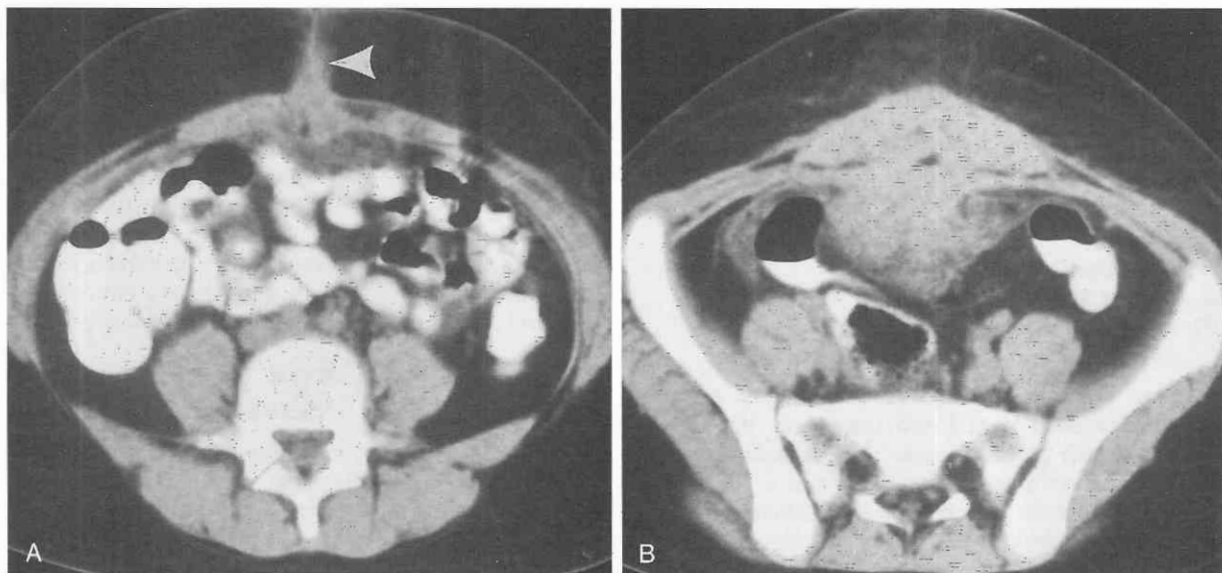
Pyourachus on serial CT scans. A, CT scan just below the level of the umbilicus shows a thickened fistulous tract (arrowhead) between the anterior abdominal wall and the rectus abdominis muscles. B, A more inferior CT scan shows inflammatory infiltration of the abdominal wall as well as a large heterogeneous midline mass deep to the rectus muscles.
